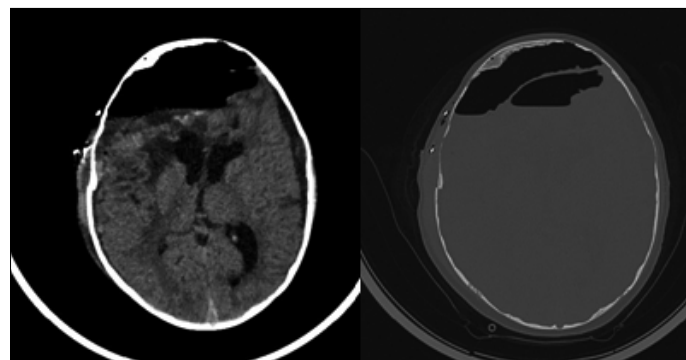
Postoperative noncontrast computed tomography of the head.
